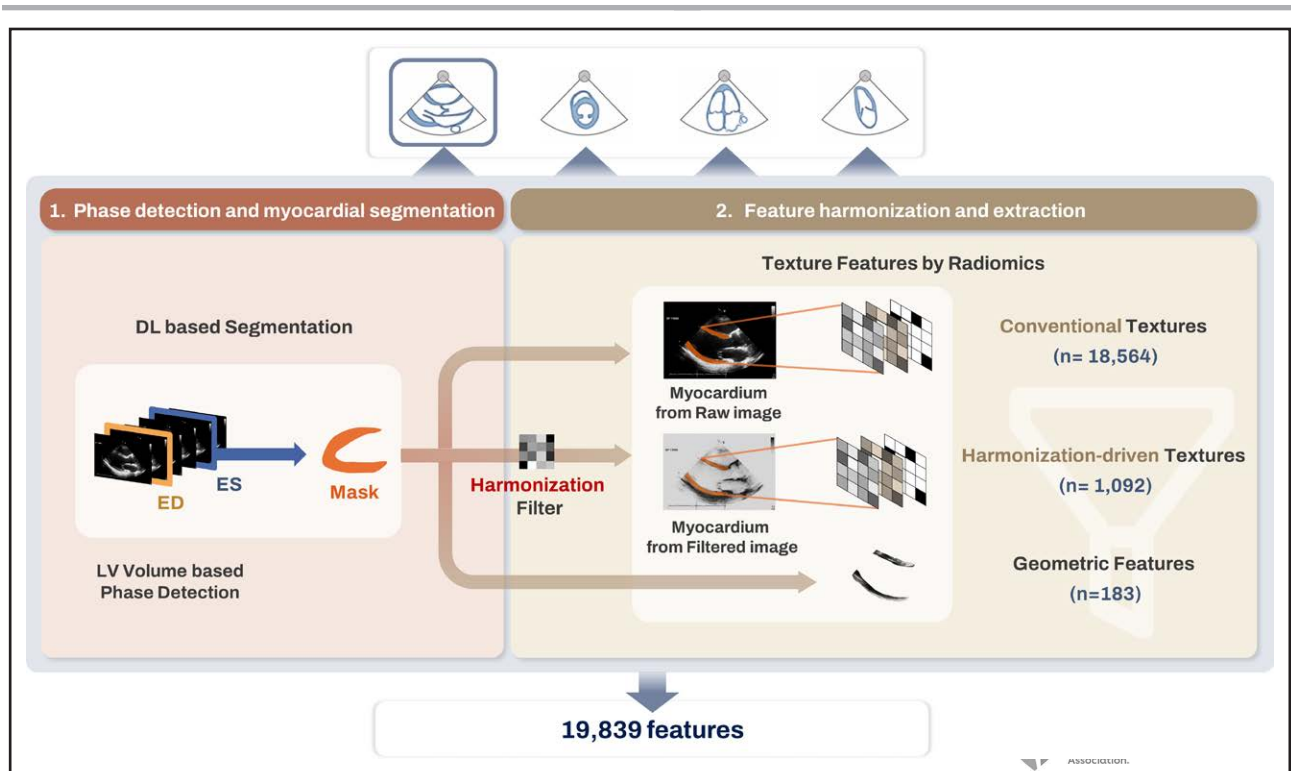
Automated process of echocardiographic feature extraction for developing the classification model.
